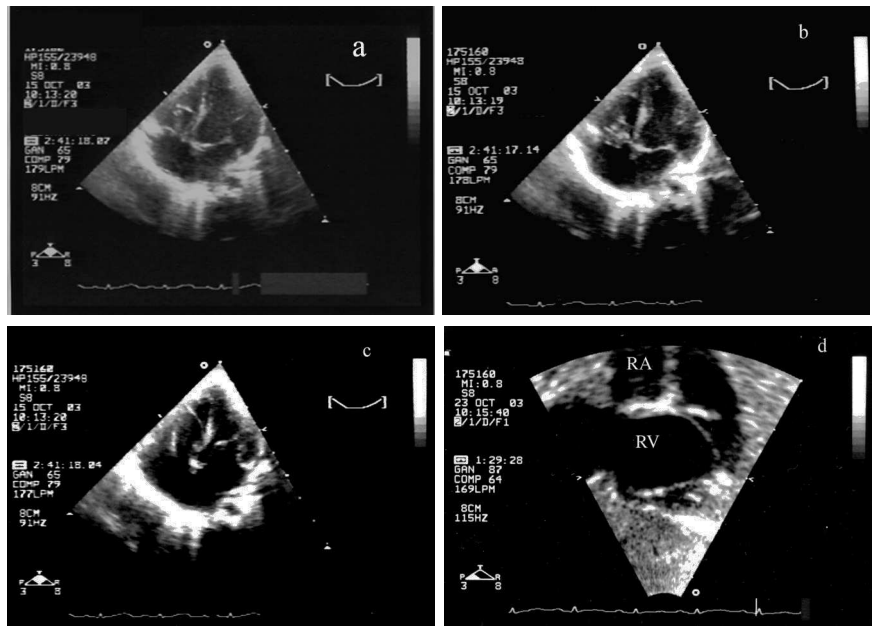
Apical echocardiographic views (diastole [c] systole [a,b]) and inverted subcostal [d] showing an apparently dysplastic tricuspid valve.
